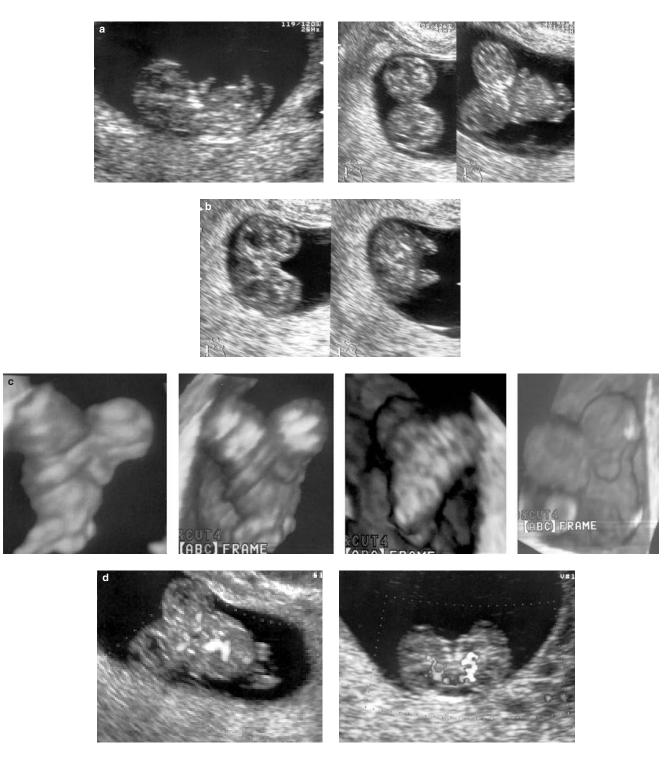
(a) Conjoined twins at 12 weeks' gestation. 2D transvaginal sonography. Left image shows sagittal section through the conjoined twins, revealing an almost normal appearance. If one concludes on the basis of this section, the diagnosis of conjoined twins is missed. Middle image shows transverse sections through fetal heads which reveal two apparently normal heads adjacent to each other. Right image shows a coronal section which reveals a fetus with two heads and a single trunk, indicative of conjoined twins. (b) These images show transverse sections through the fetal head and abdomen which reveal two normal heads adjacent to each other. At the base of the head, the twins have a common thorax and abdomen. (c) 3D scan of same conjoined twins shown in a and b. Surface-rendered reconstruction of the conjoined twins is useful for the diagnosis of thoracophagus. Unfortunately, no information about the shared inner organs can be obtained due to limited visualization of superficial structures. (d) Conjoined twins at 12 weeks' gestation. 2D power Doppler. Power Doppler analysis can delineate the extent of organ sharing in the first trimester, an essential step for appropriate management of this anomaly. The coronal section (left) shows shared fetal circulation within a single heart. On transverse section (right) separated cerebral circulations are clearly visible
